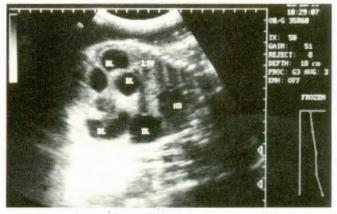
Showing ultrasonography of patient with multiple fluid levels in the fetal ileum in utero.
